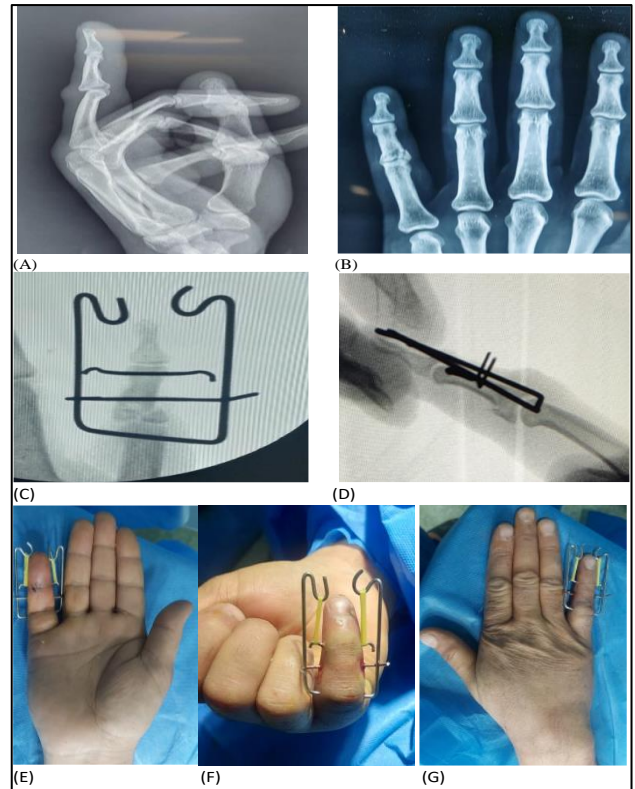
(A-G): 40-year-old male with fracture base of middle phalanx of little finger. Pre-operative lateral view, pre-operative antero-posterior view, intra-operative AP and lateral radiographs with Suzuki's frame *in situ* and clinical photos of the Suzuki's frame.
